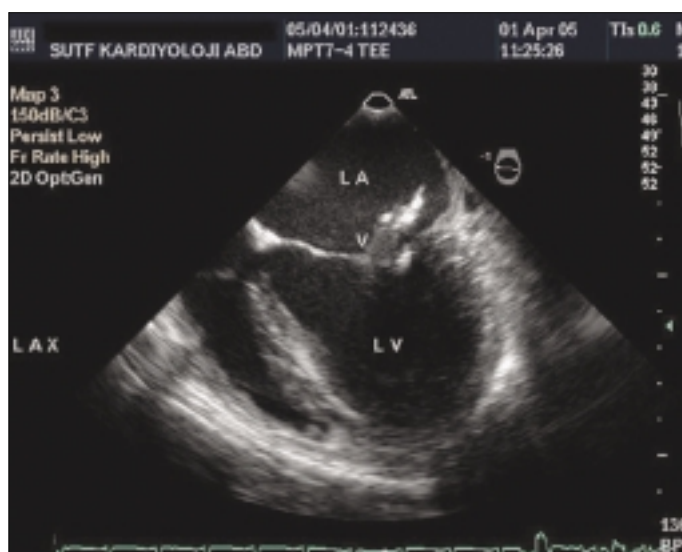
Transesophageal echocardiography view of the vegetation (V) on the posterior leaflet of the mitral valve
